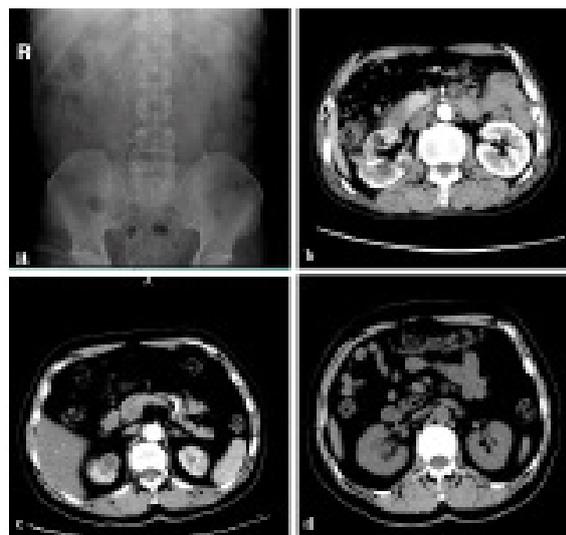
Computed tomography in a ureteropelvic joint stone with ipsilateral renal cyst.
